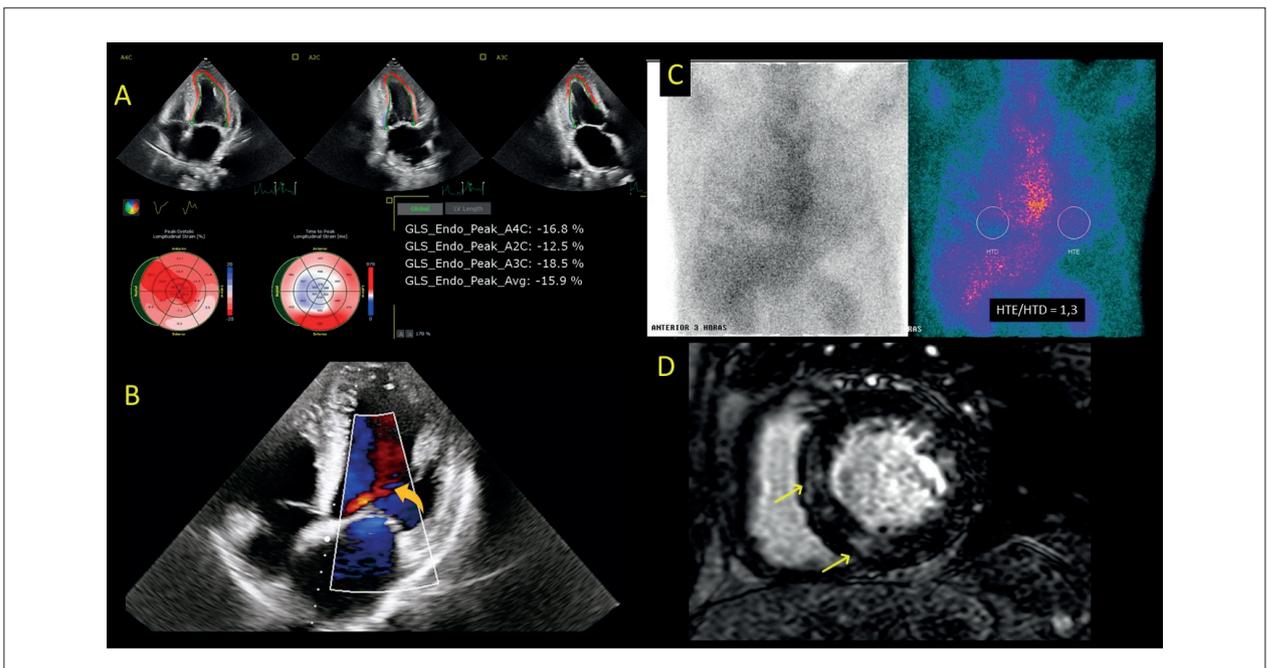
(2A): Echocardiogram showing GLS of 15.9% with apical sparing pattern. (2B): Echocardiogram (5-chamber view) with color Doppler showing AR (orange arrow). (2C): Technetium-pyrophosphate cardiac single-photon emission computed tomography (Tc-PYP SPECT) revealing heart uptake equal to rub uptake (grade 2 visual scale) and quantitative analysis with heart-to-contralateral lung uptake ratio (H/CL) of 1.3 in the third hour. (2D): Cardiac MRI reveals mild irregular and diffuse areas of late gadolinium enhancement within basal and mid segments of the LV (yellow arrows).
